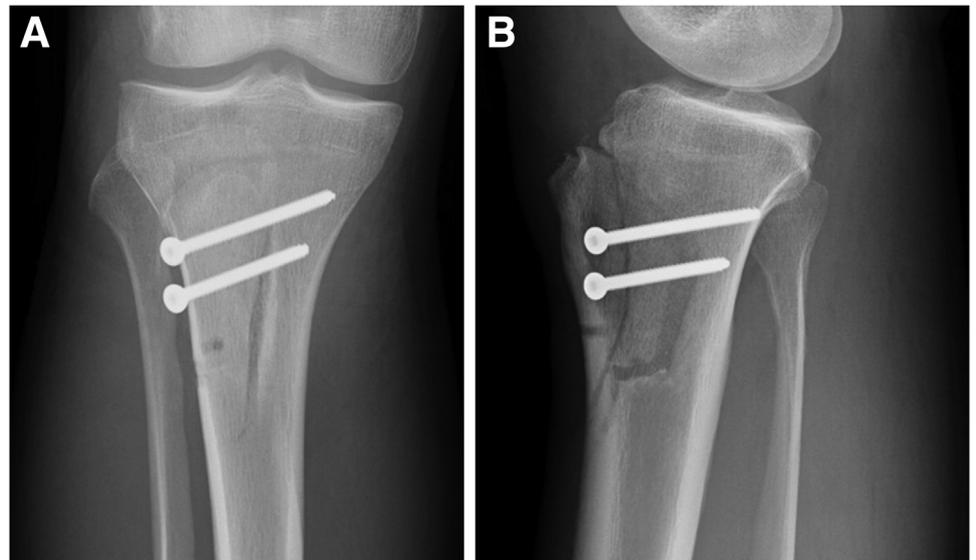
Postoperative radiographic images of an (A) anteroposterior and (B) lateral view of the knee showing fixation of the pure anteriorization tibial tubercle osteotomy. These images show predrilling of the distal/anterior cortex to facilitate hinging of the osteotomy fragment.
